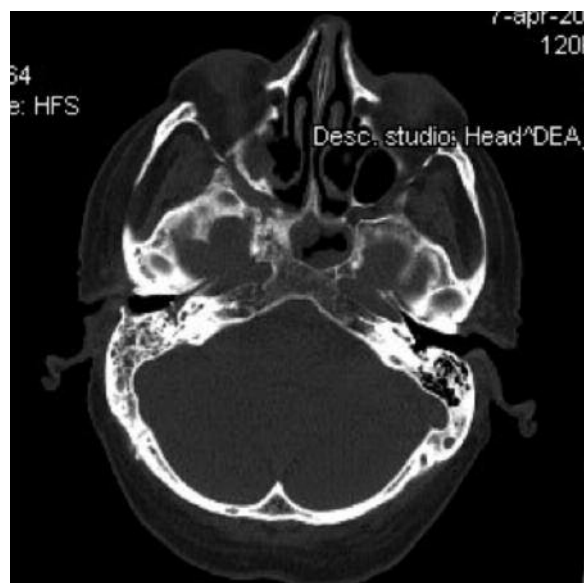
Assial CT scan of patient 1 showing the interest of maxillary pterygoid junction and sphenoidal pterygoid processes until skull base area.
